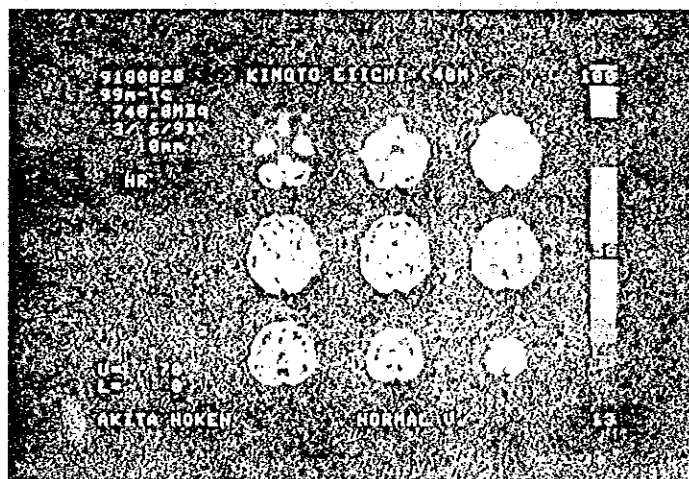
SPECT images using $^{99\text{m}}\text{Tc}$ -HM-PAO
